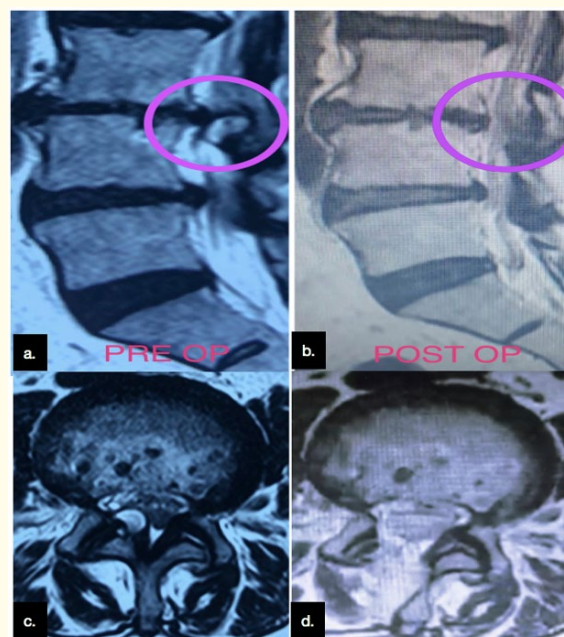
83 years old male operated with uniportal interlaminar FESS for L3-L4 LCS with right sided facetal cyst. Preoperative (figure a and c) and postoperative (figure b and d) MRI showing good decompression and complete excision of the facetal cyst.
